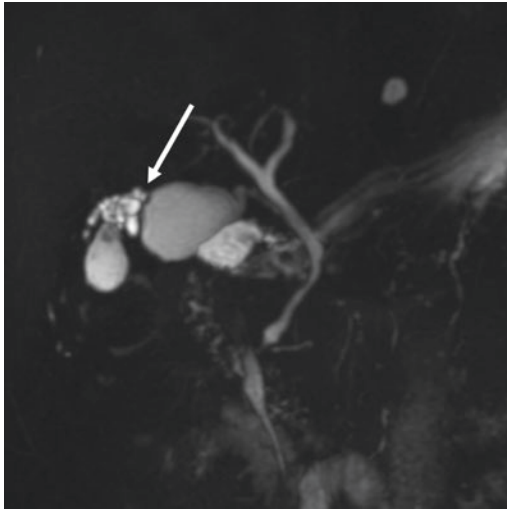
Dynamic CT image of adenomyomatosis. Gallbladder shows waisted shape with multiple RAS structures (arrow)
